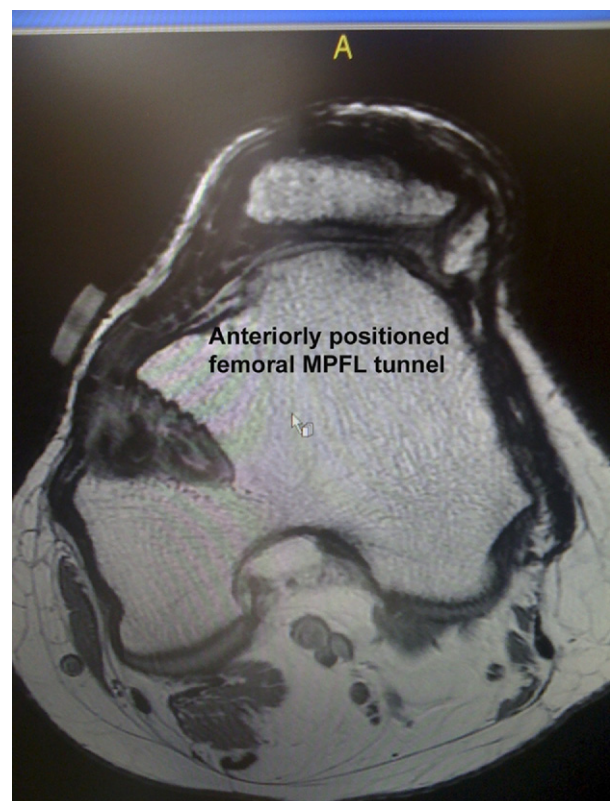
Axial MRI scan showing an anteriorly positioned femoral tunnel in a 33-year-old woman after an allograft MPFL reconstruction (case 2). Significant medial patella facet arthritis and medial tilt developed from her over-tightened and malpositioned MPFL graft.
